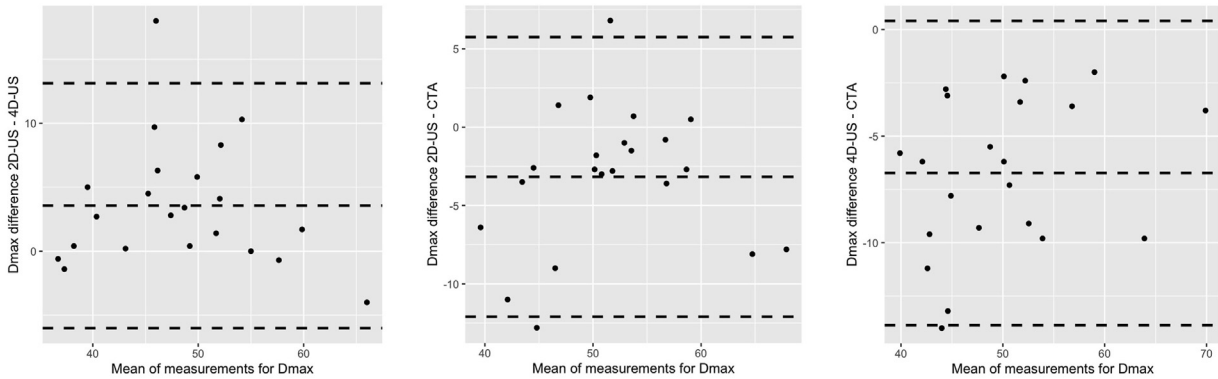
Bland Altman plots for measurements of maximum abdominal aortic aneurysm (AAA) diameter (DMax) in two-dimensional ultrasound (2D-US), four-dimensional ultrasound (4D-US), and computed tomography angiography (CTA).
